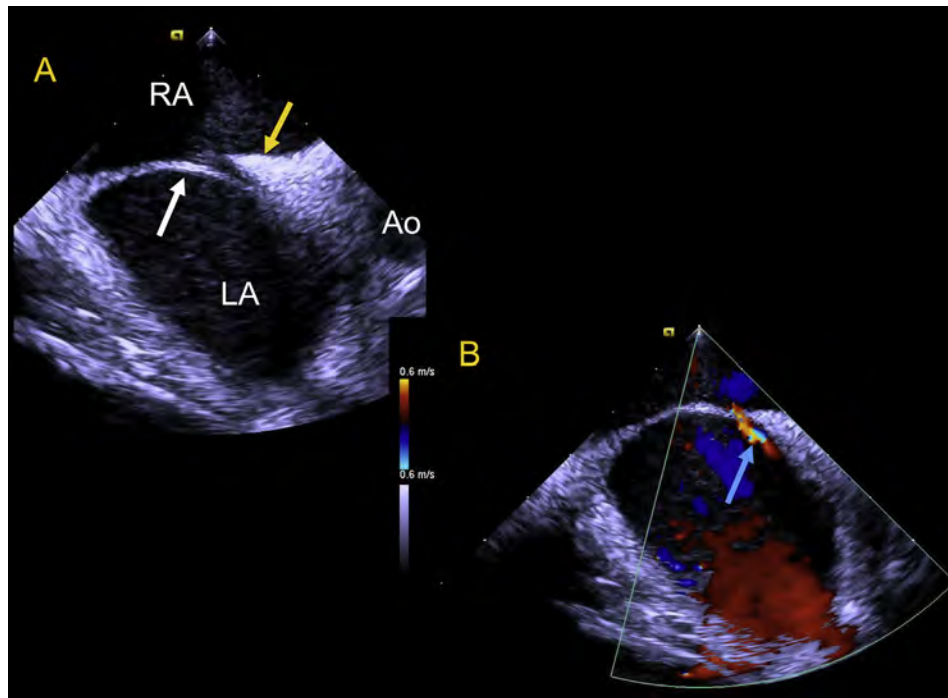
(A) Two-dimensional ICE of a “stretched” PFO and (B) with color Doppler in an adult patient. Yellow arrow indicates the septum secundum; white arrow, septum primum; blue arrow, left to right flow through PFO. See also [Video 2](#).
